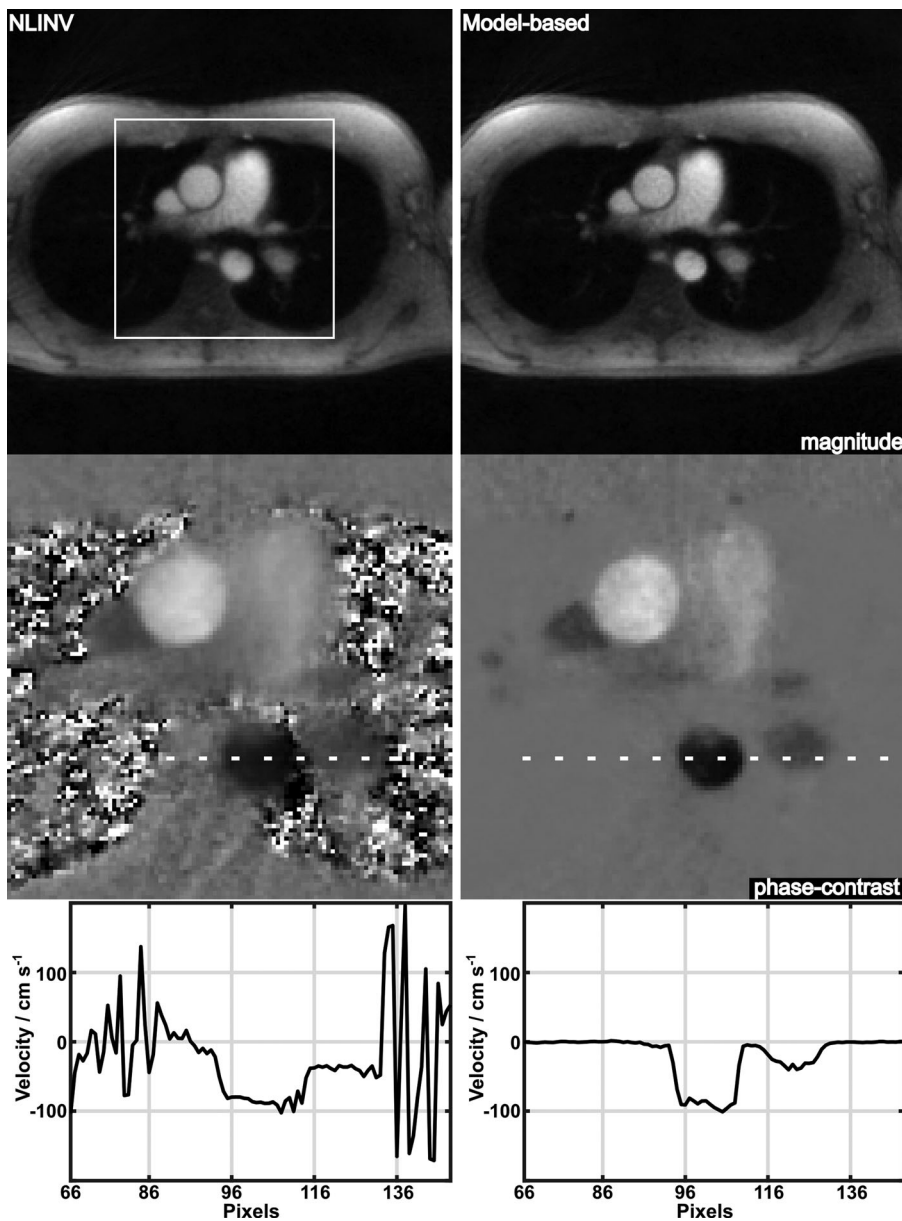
NLINV (left) and model-based (right) reconstructions of systolic magnitude images and phase-contrast maps (magnified views) (top) as well as velocity profiles (along indicated reference lines) for real-time phase-contrast MRI of aortic blood flow in a healthy volunteer at 35.7 ms resolution and $VENC = 200 \text{ cm s}^{-1}$.
